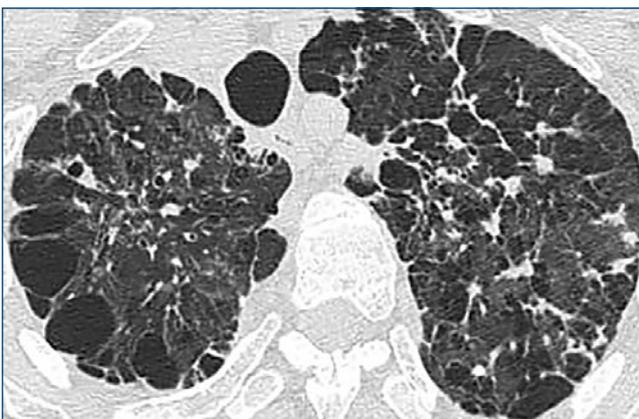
a, b, c, d. CT scan: diffuse interstitial fibrosis, pulmonary cysts, bronchiectasis, and ground-glass opacities.
